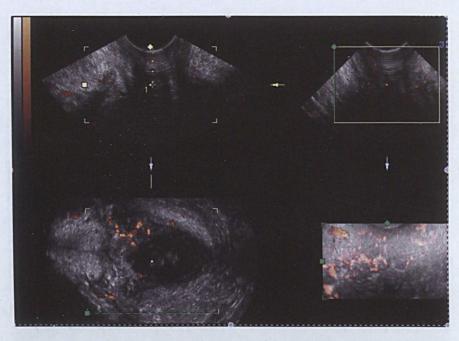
Experimental Design 2. 3D image acquired using power Doppler from a pre-operative patient.
